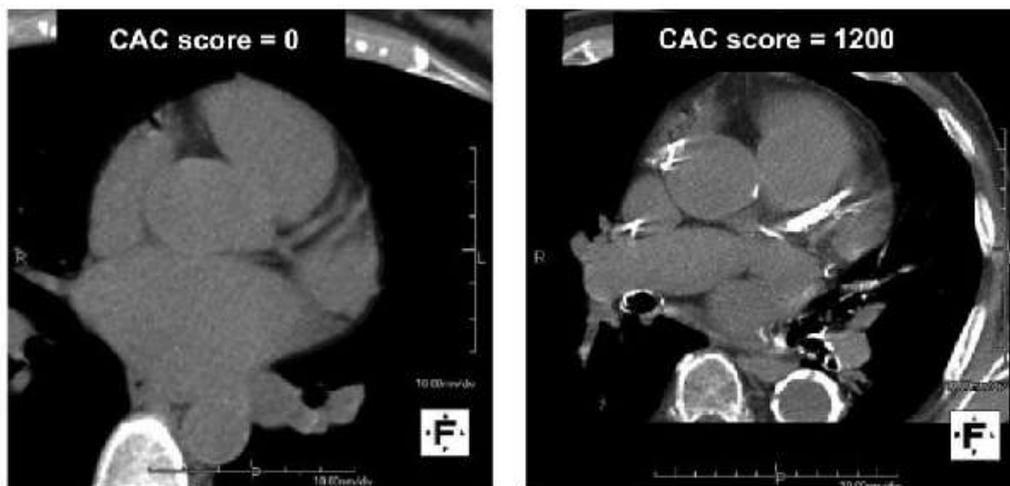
CT showing calcified plaques in coronary arteries
